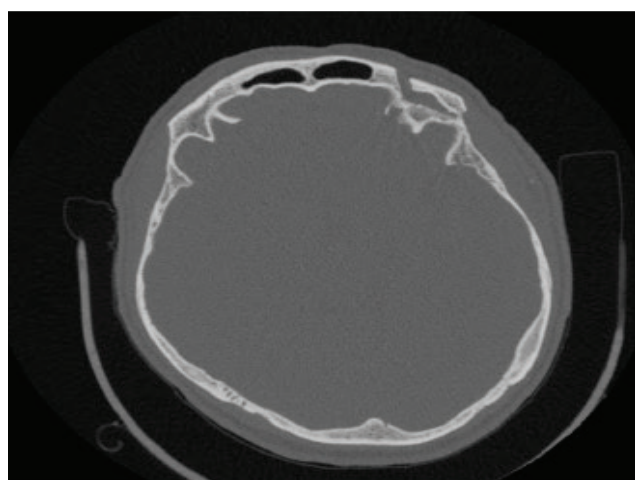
Axial CT showing fracture of the superior orbital rim.
